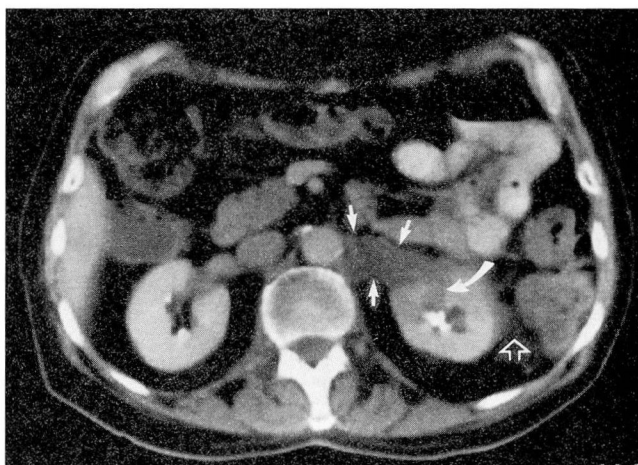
Contrast-enhanced CT scan through the upper kidneys (same level as in *Figure 1*) obtained after 1 month of treatment demonstrates small residual low attenuation masses in the left periaortic region (solid arrows) and in the anterior aspect of the left kidney (curved arrows). A residual tumor is also present in the left perinephric space immediately adjacent to the left kidney (open arrow). Note that the kidneys have returned to their normal configuration.
